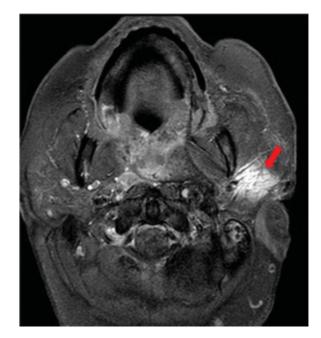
A transverse T2-weighted MRI of the skull base showing the lesion expressed as the region of high signal intensity in the left infratemporal fossa (red arrow). MRI, magnetic resonance imaging.
